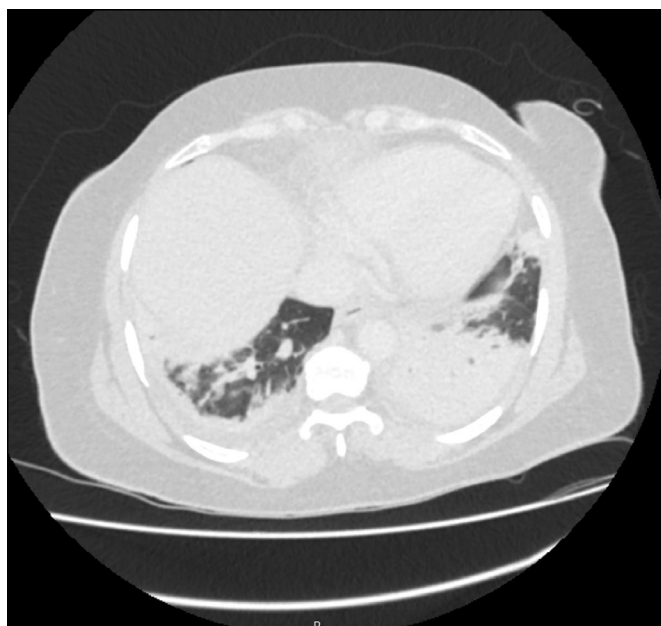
CT of the abdomen and pelvis during admission capturing lung bases, showing bibasal consolidation with small pleural effusions.
